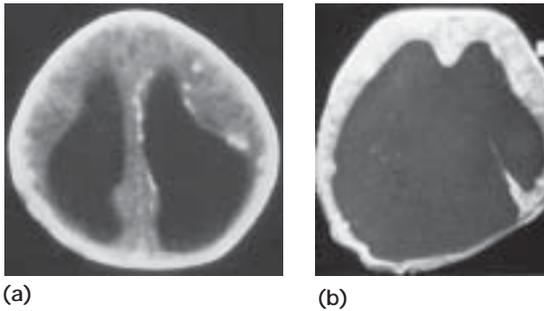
a CT scan head showing brain damage due to fetal infection. b MRI brain showing semilobar holoprosencephaly.
